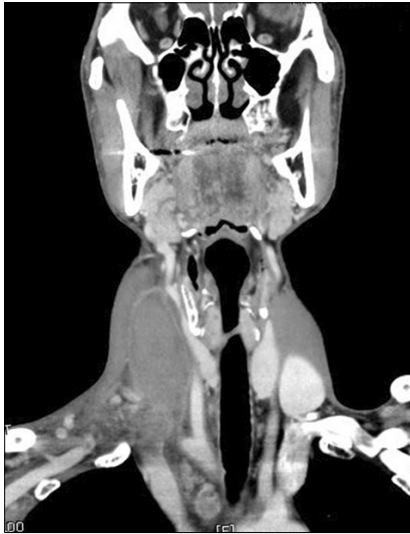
Neck CT showing thrombosis of the right internal jugular vein and swelling of the right neck.
